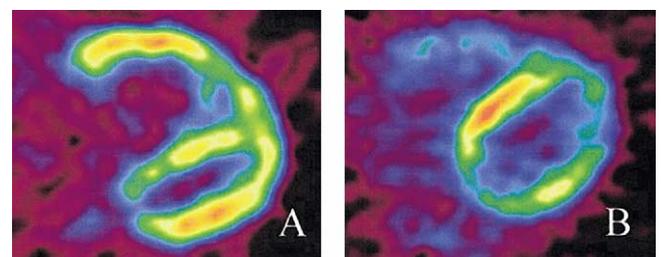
Representative midventricular transaxial FDG PET images of a patient with primary pulmonary hypertension before and after the pulmonary vasodilator therapy with epoprostenol for three months. Before the pulmonary vasodilator therapy, the RV FDG accumulation was highly increased and the corrected RV SUV of FDG was 13.4 (A). After the therapy, the corrected RV SUV of FDG markedly decreased to 7.5 (B). Abbreviations as in Figures 1 and 2.
